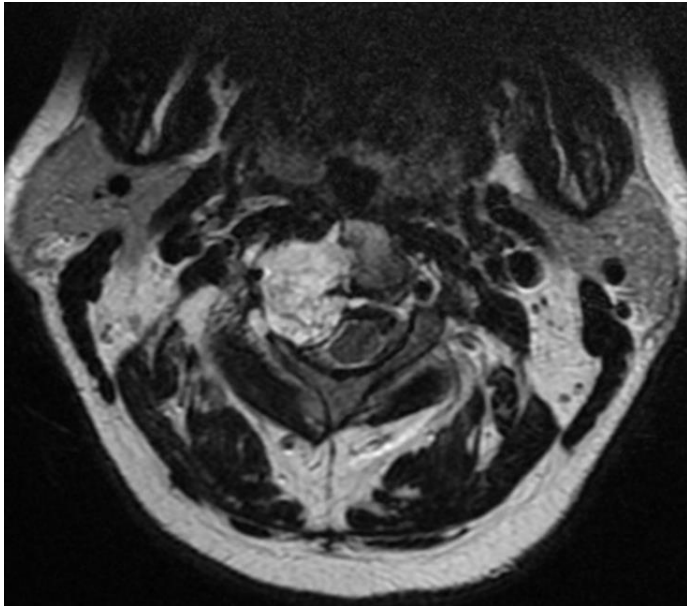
Axial MRI of the C2 level showing a right-sided chordoma with epidural extension and compression of the right vertebral artery
